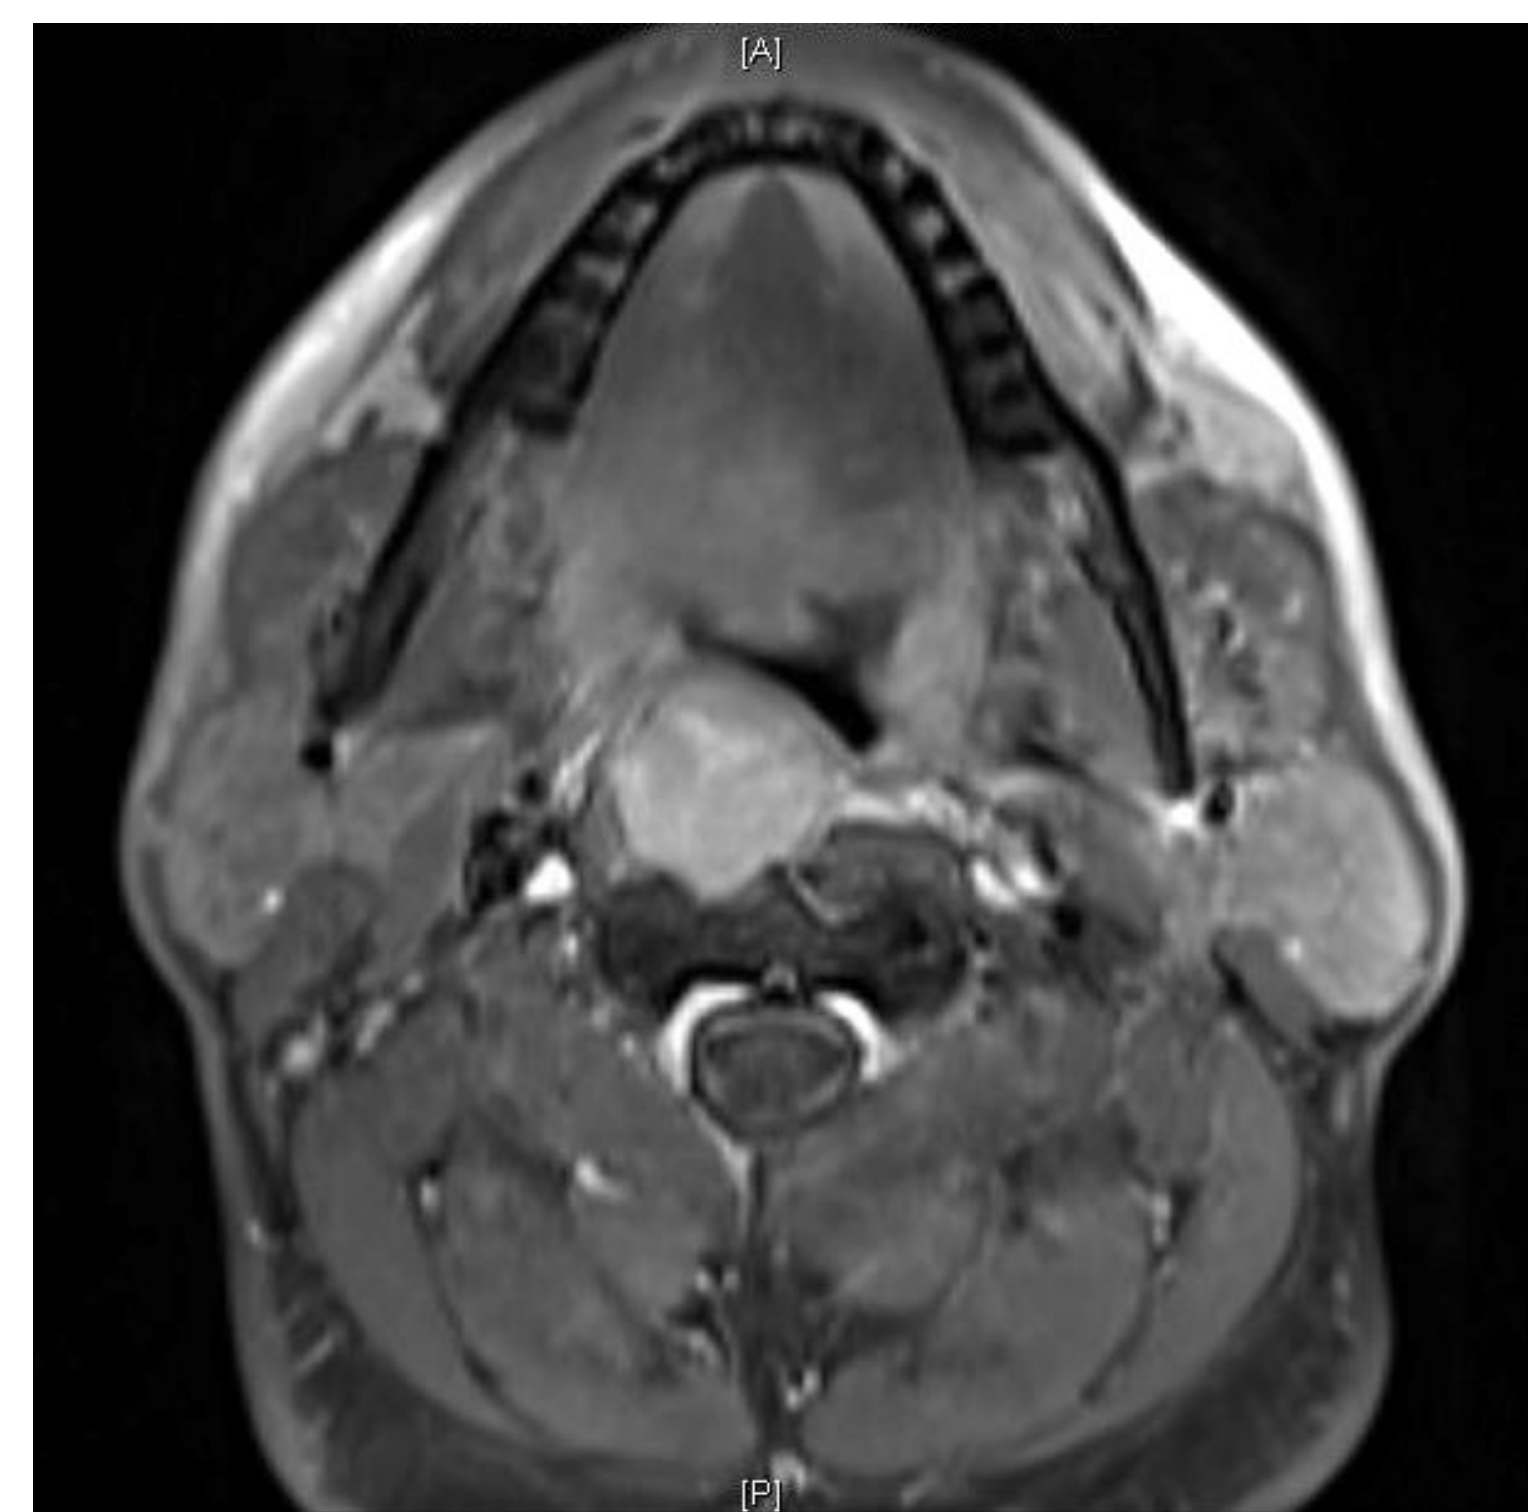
MRI neck with contrast with axial view, T1 post-contrast. There is a 2.6 x 2.7 x 4.3 (transverse x AP x CC) mass in the right prevertebral space at C2 causing anterolateral displacement of the right longus colli and longus capitis muscles.
